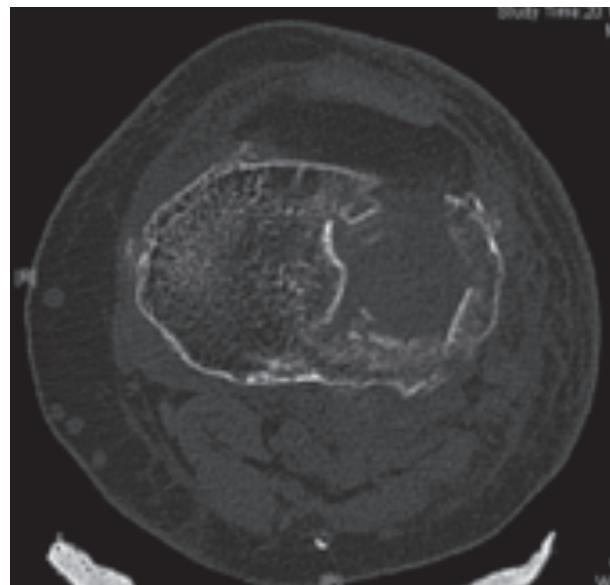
Case 1 – CT Scan showing lateral depression fracture of left knee and poor bone stock.
